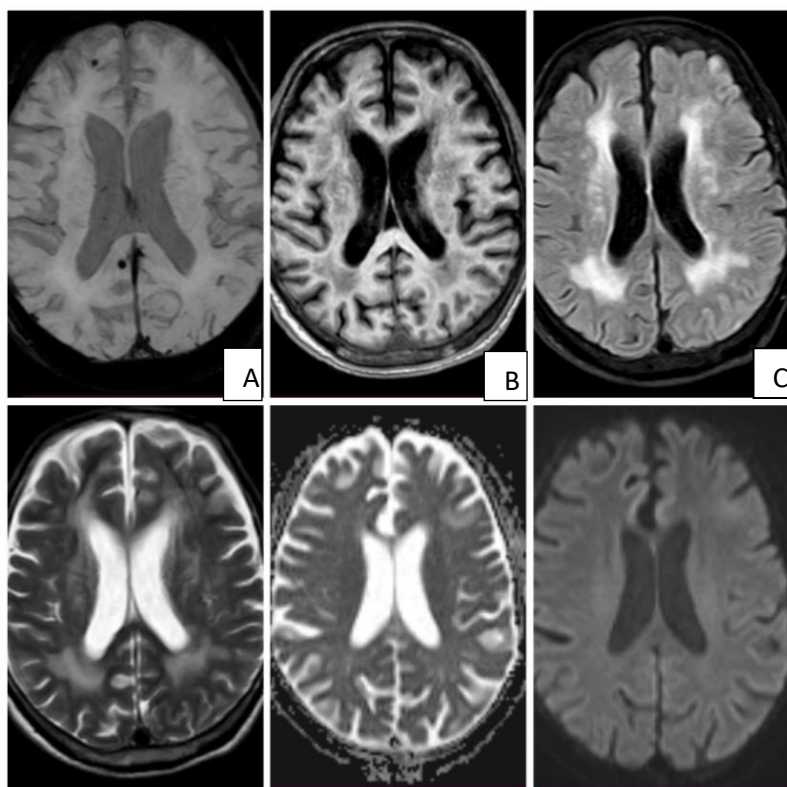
Small focal hemorrhagic lesion in 50-year-old male patient in right frontal and parietal lobe exclusively identified on SWI (A). Lesion not apparent on T1 (B), T2 (D), FLAIR (C), DWI (E/F)
